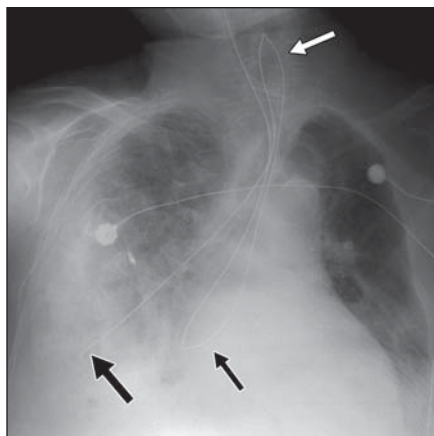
60-year-old woman with malpositioned nasogastric tube. Anteroposterior chest radiograph shows looped nasogastric tube (*thin black arrow*) projecting in mid esophagus. After second looping in neck (*thin white arrow*), tube has entered bronchial tree, and its tip (*thick black arrow*) projects over right lower lobe. Note increased right lower lobe airspace opacities due to pulmonary contusion or pneumonia and right pleural effusion.
